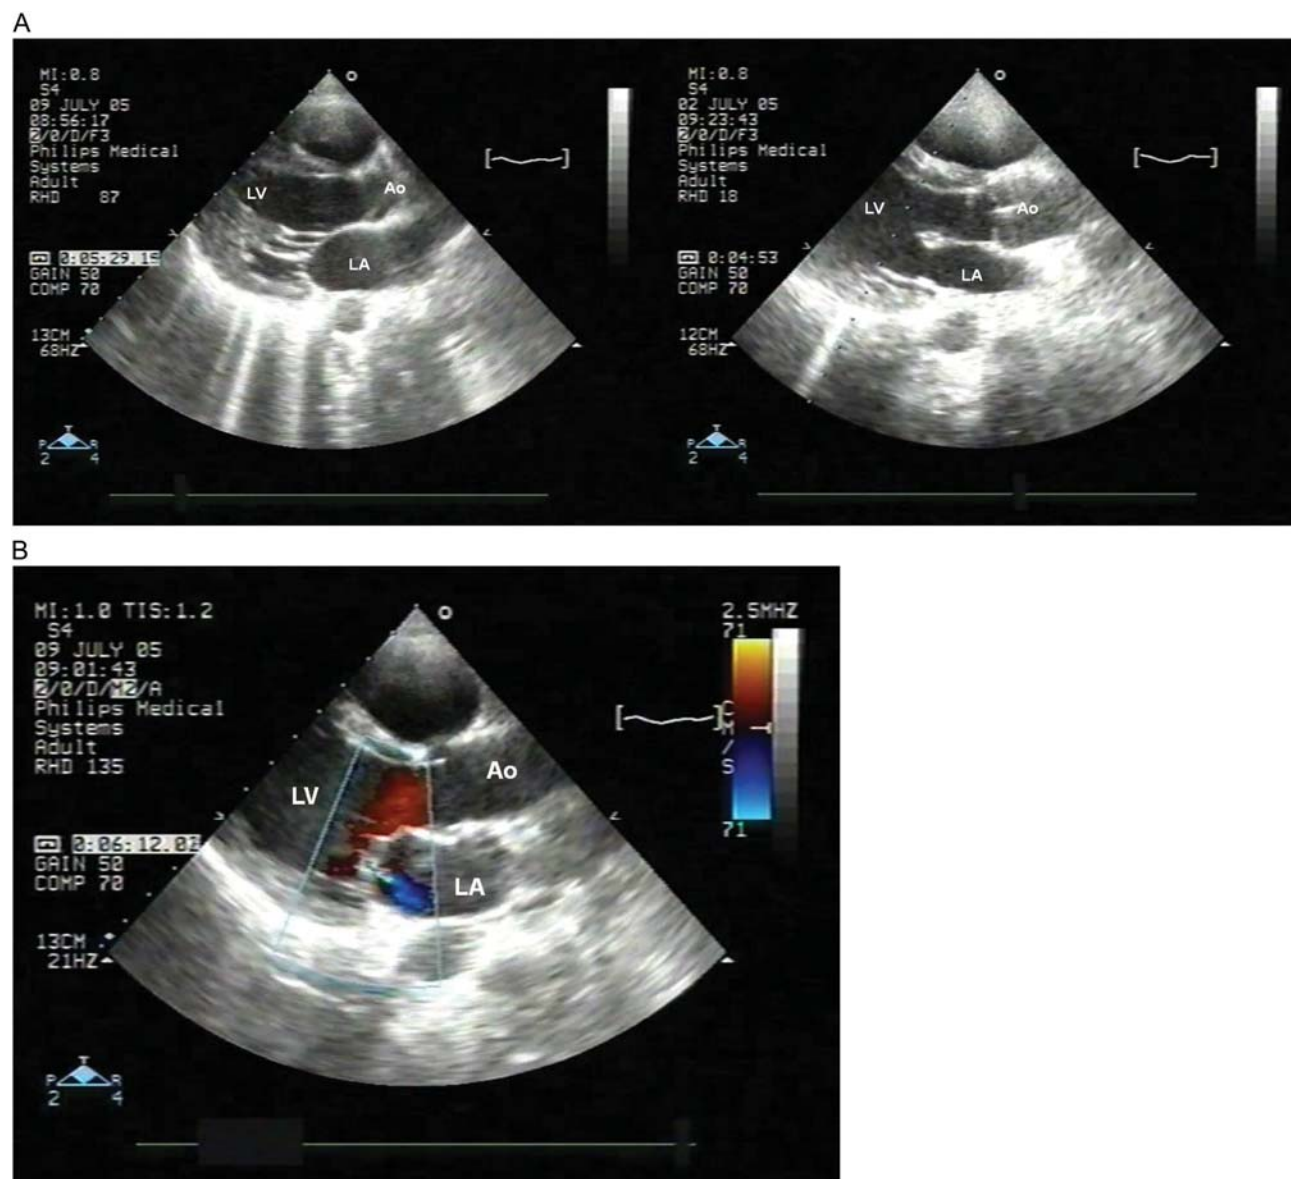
(A) Trans-thoracic echocardiography: parasternal long-axis view in a case meeting the reference criteria. Morphological features were in the presented case: (i) prominent thickening, and shortening of chordal structures (left panel), and (ii) marked thickening of the margins (right panel). Ao, aorta; LA, left atrium; LV, left ventricle. (B) Trans-thoracic echocardiography: parasternal long-axis view in a case meeting the 'simplified' criterion (i.e. MR jet length ≥ 2 cm). Ao, aorta; LA, left atrium; LV, left ventricle.
